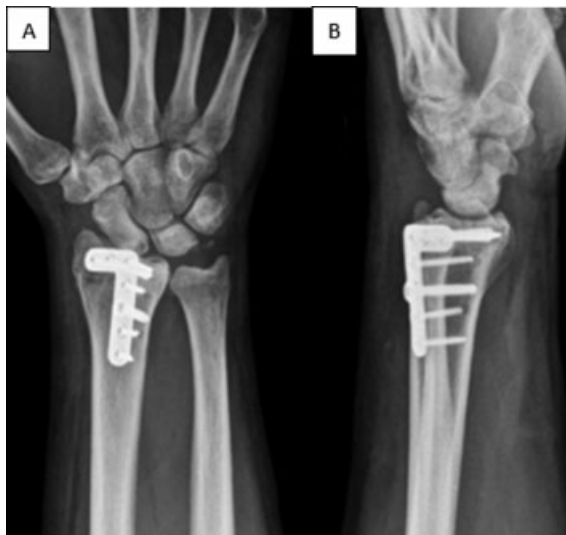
Posteroanterior (A) and lateral (B) radiographies of the distal portion of the right radius showing vicious consolidation with radiocarpal joint step and loss of normal radial volar tilt.
